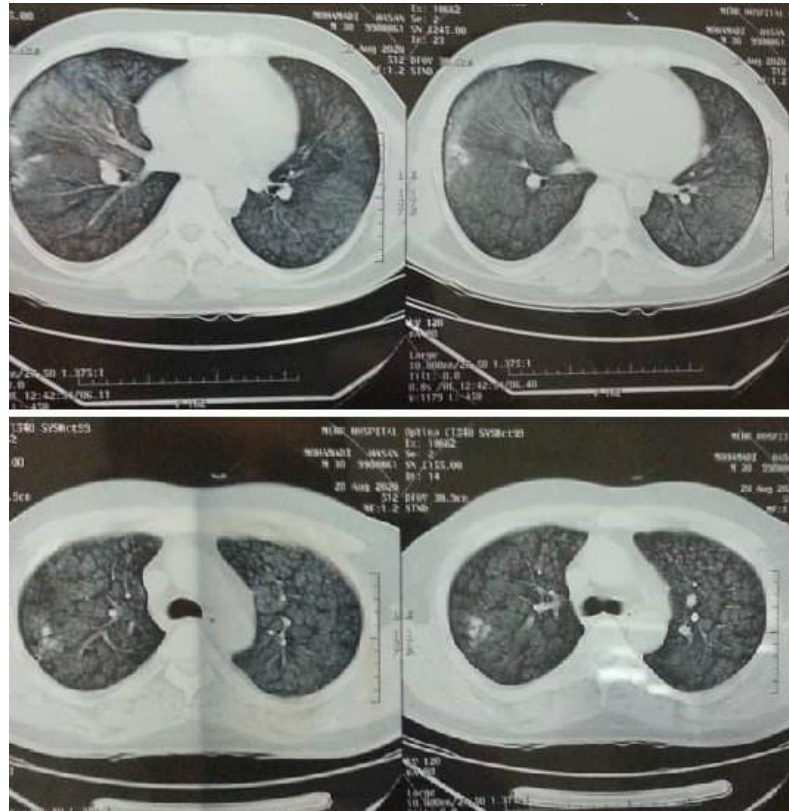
The high resolution computed tomography of chest revealed numerous centrilobular and ground-glass infiltrates in both lungs.
